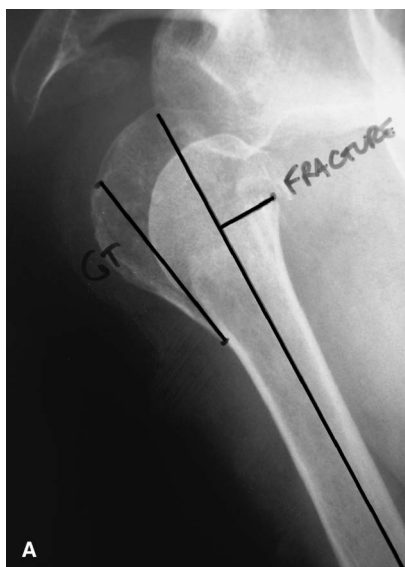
A, N = Entire length of normal humerus along perpendicular from medial epicondyle to top of humeral head. Use scaled ruler on X-ray to calculate radiographic magnification and obtain actual number. B, F = Length of injured humerus along perpendicular from medial epicondyle to fracture at superior edge of medial calcar. Use scaled ruler on X-ray to calculate radiographic magnification and obtain actual number. C, N minus F = H. H is the Fracture to Top of Head Height. D, Fracture to Top of Head Height is marked on actual prosthetic implant.
